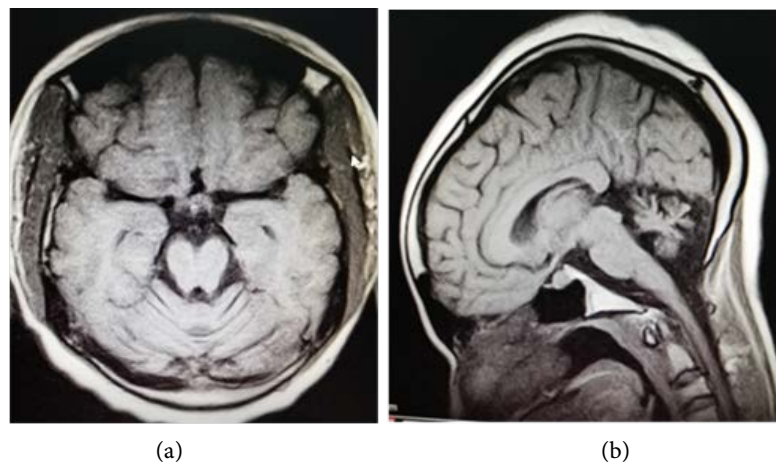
Brain MRI of the patient showing cerebellar hypoplasia with normal cerebrum, brain stem and ventricle. Informed consent was obtained from the patient to allow data and image publication.
